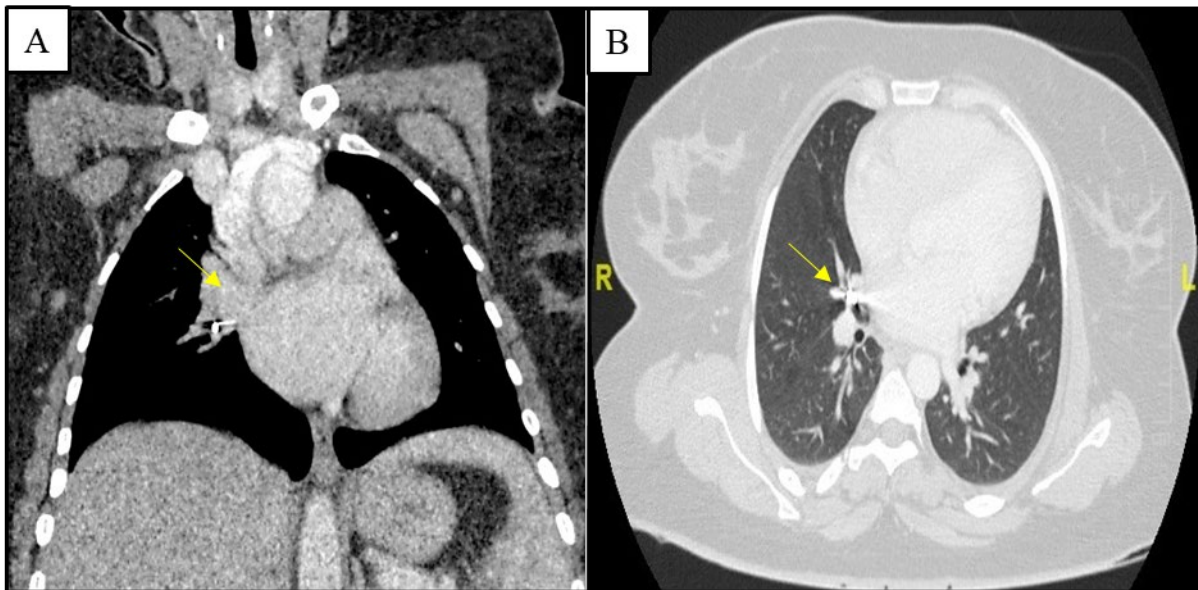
Computer tomography image and image of foreign body. (A) Contrasted computed tomography of thorax (mediastinal window) in coronal view demonstrating foreign body in the right main bronchus. (B) Contrasted computed tomography of thorax (lung window) in axial view demonstrating foreign body in right main bronchus.
